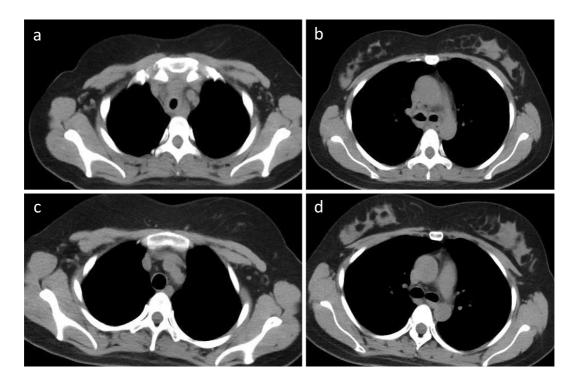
CT scans on admission (a, b) and after treatment (c, d).
